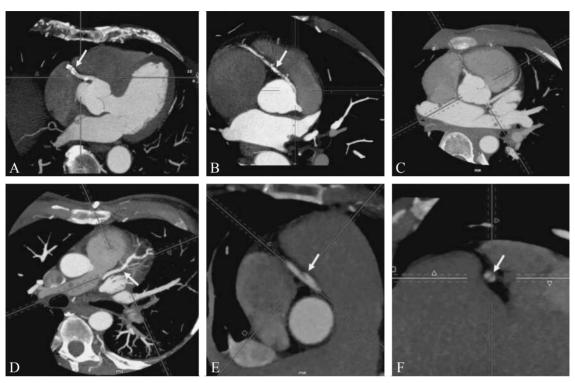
Possible CTA findings in patients admitted in emergency department for acute chest pain: A) multiples calcified plaques in the proximal RCA causing 50% stenosis; B) abnormal origin of RCA from the left coronary sinus with proximal sub-occlusive mixed plaque; C) normal coronary arteries; D) small lipid plaque in the mid-segment of the left anterior descending coronary artery; E) and F) proximal right coronary artery dissection.
